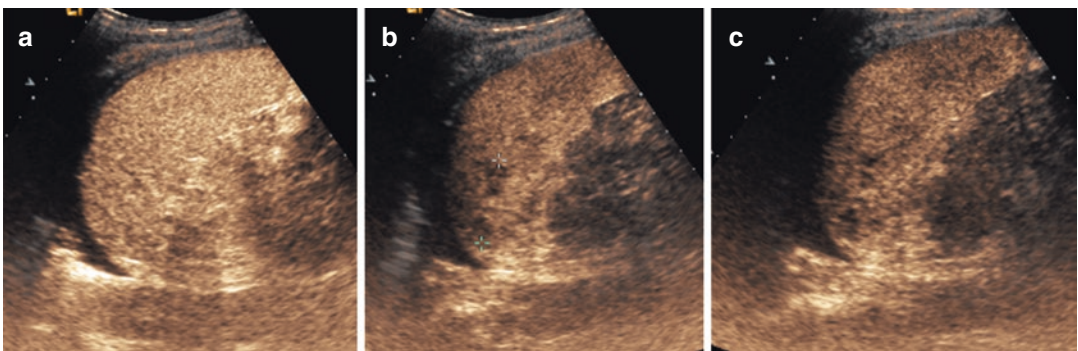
(a–c) CEUS performed the following day confirms the heterogeneous areas of the upper pole and middle of the spleen, referring to the lacerations already documented in the previous CT examination. CEUS also delineates a subtle subcapsular hematoma
